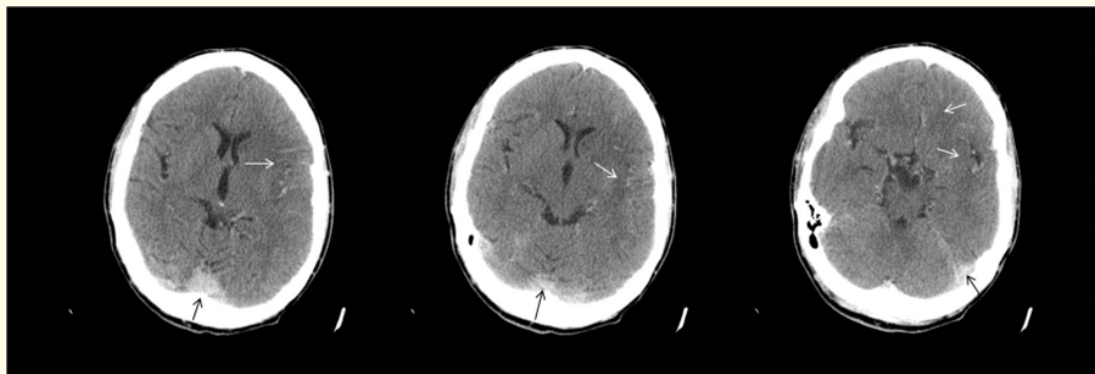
Three cuts from primary axial CT imaging of the patient presented to the Emergency department with probable clues to CSVT (black arrows indicate possible cord sign) and SAH (white arrows indicate hyperdensities in fissures).
